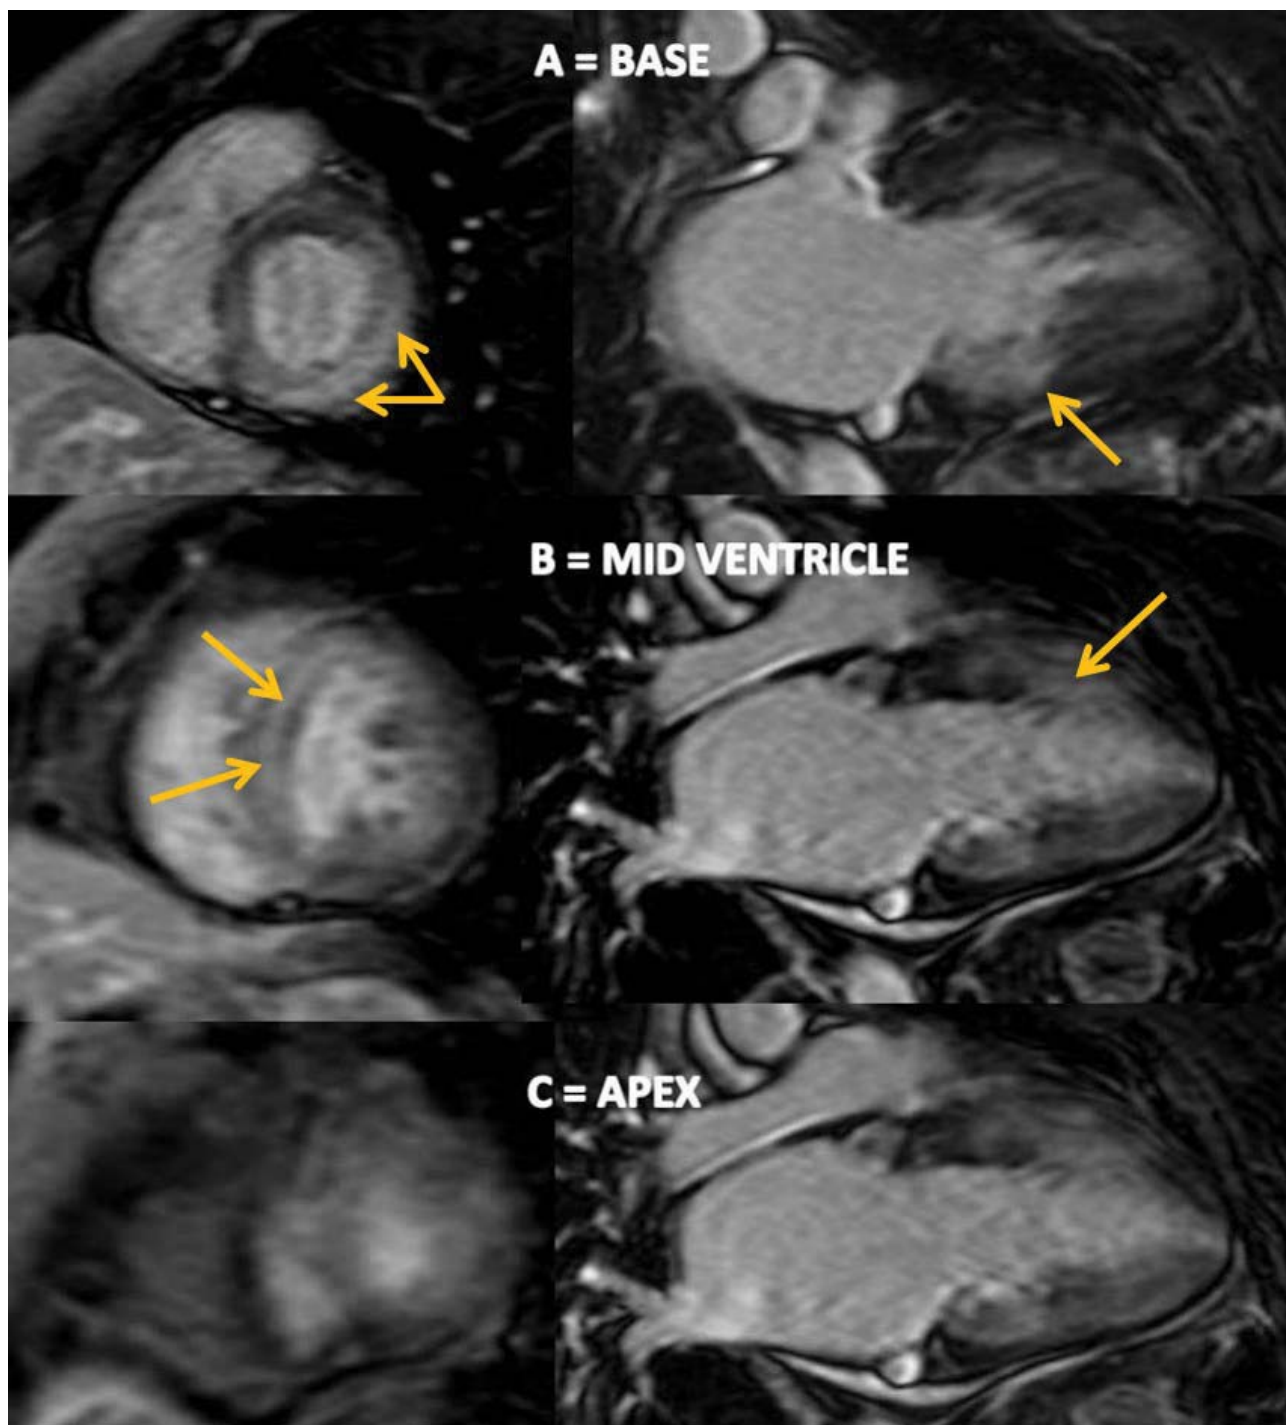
Cardiac magnetic resonance images showing A and B diffuse subendocardial LGE at the base and mid-ventricle in the left ventricle (yellow arrows). C no LGE of the apex. LGE: late-gadolinium enhancement.
